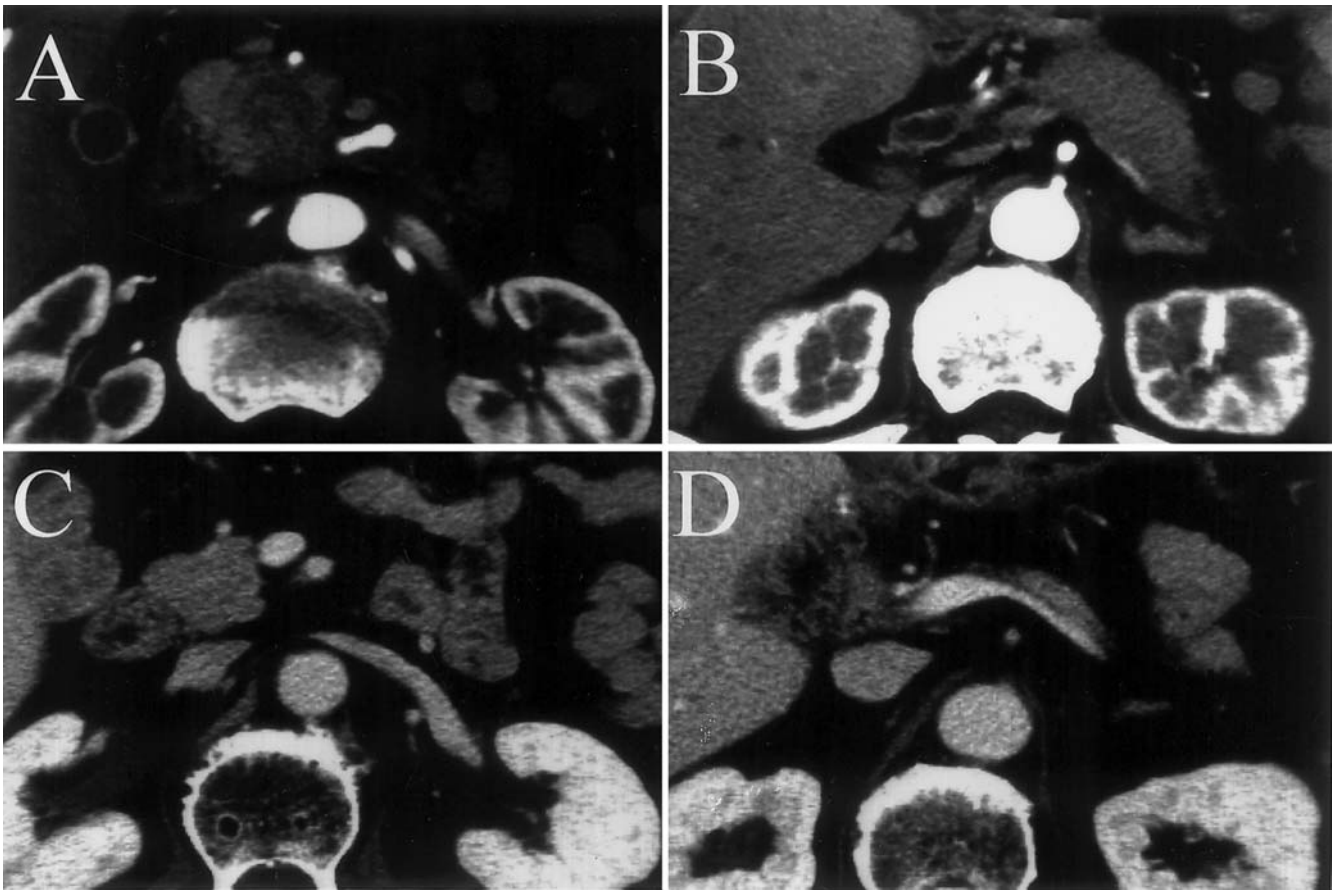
Enhanced abdominal CT scans before (A,B) and after steroid therapy (C,D). The pancreas showed marked regression of size
